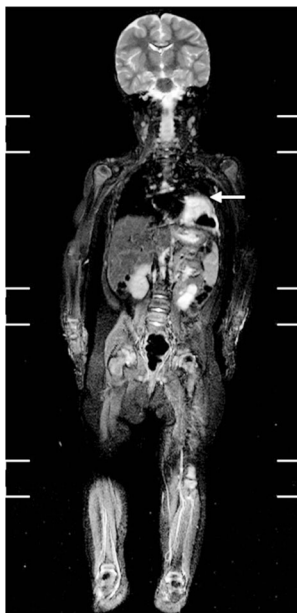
Example of findings on whole-body MRI using coronal short tau inversion recovery (STIR) sequence, performed as part of the surveillance protocol for patients with DICER1 syndrome, in a 23-month-old girl (patient 10) with developmental delay and a confirmed *DICER1* germline pathogenic variant. The cystic and solid mass in the left lung is a pleuropulmonary blastoma first detected on this surveillance whole-body MRI (*arrow*)
